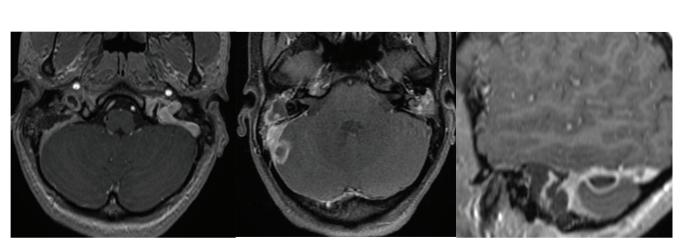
Initial MR images (T1W+C, axial and sagittal view): at the convexity of the right cerebellar hemisphere epidural empyema; the right sigmoid sinus is without normal opacification and dilated due to content of thrombus, with an erosion of the anterior wall and in continuity with right mastoid and middle ear that are filled with granulation tissue.
